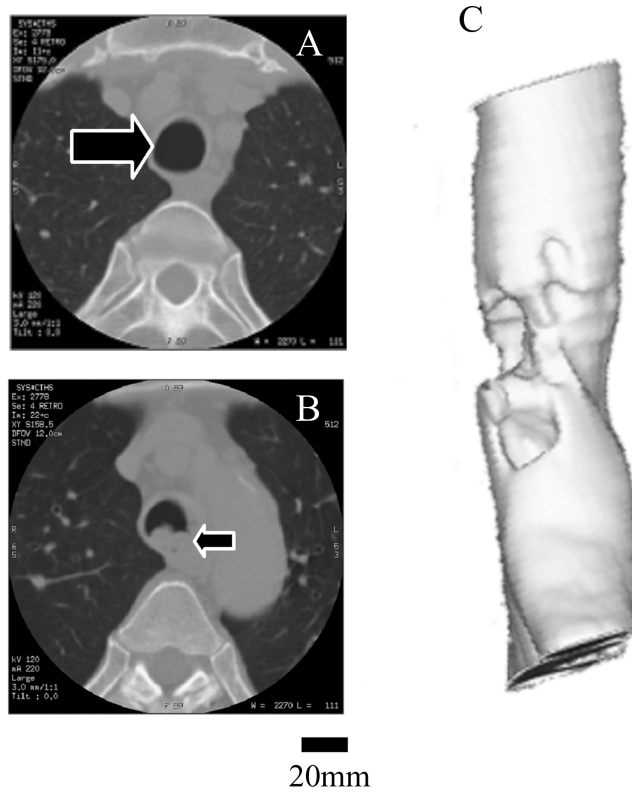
CT images showing normal (A), abnormal stenosis (B) and three-dimensional image (C). Large arrows show a trachea and small arrow shows a stenosis. The stenosis constriction was 47 %. The bottom side of A and B and the left side of C is smooth muscle side.
